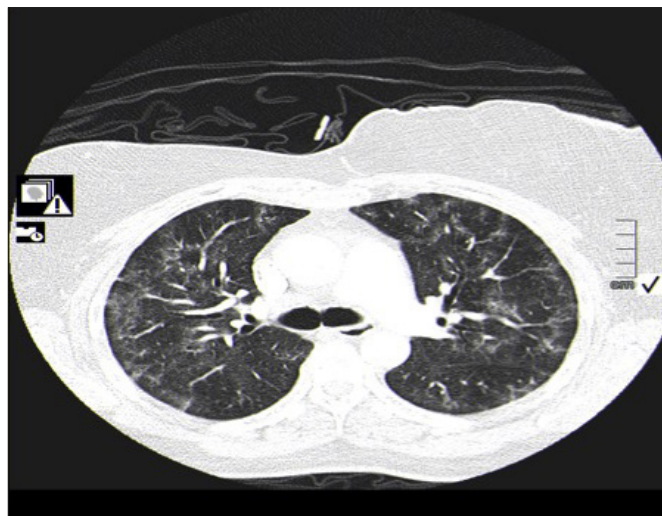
Computed tomography chest scan showing bilateral ground-glass opacities in case 2.
